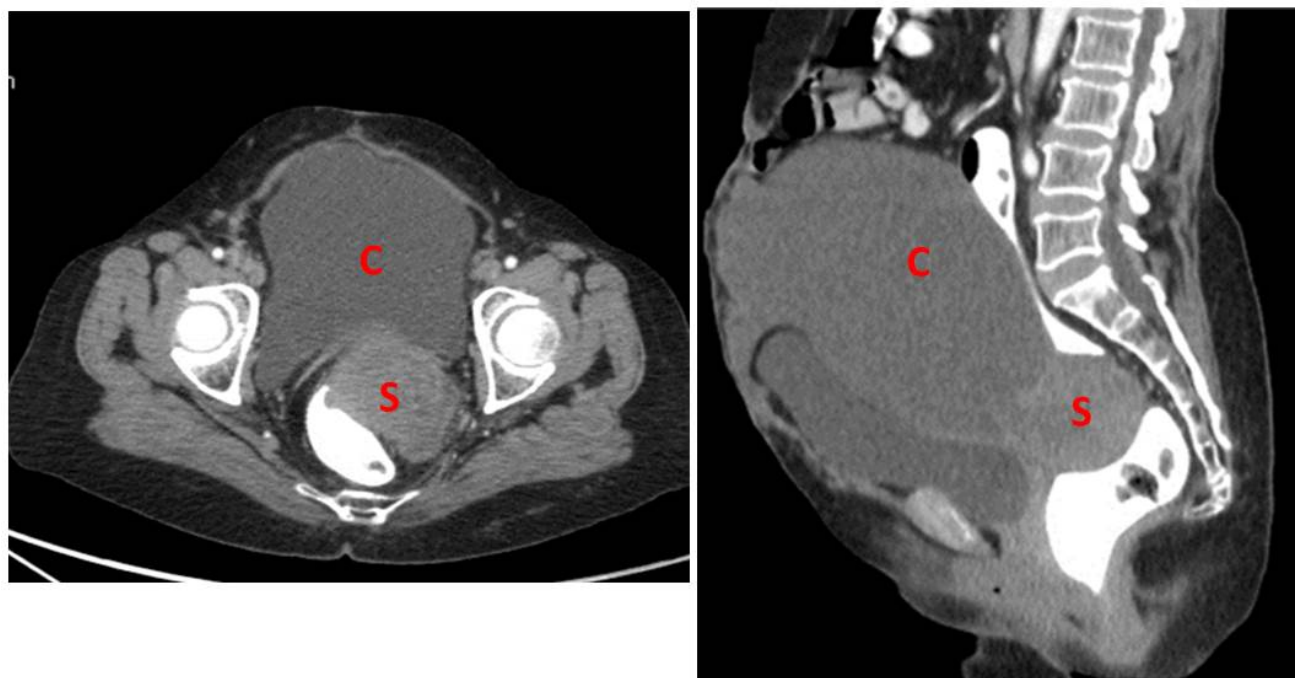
CT scan image showing large pelvic mass with cystic (C) and small deep seated solid component (S). Aspiration was done by transvaginal approach.
